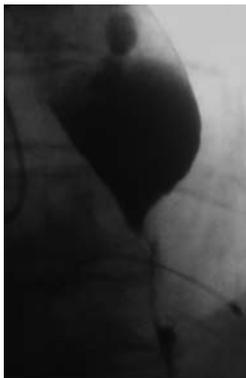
Radiographic image of the esophagus stenosis.
